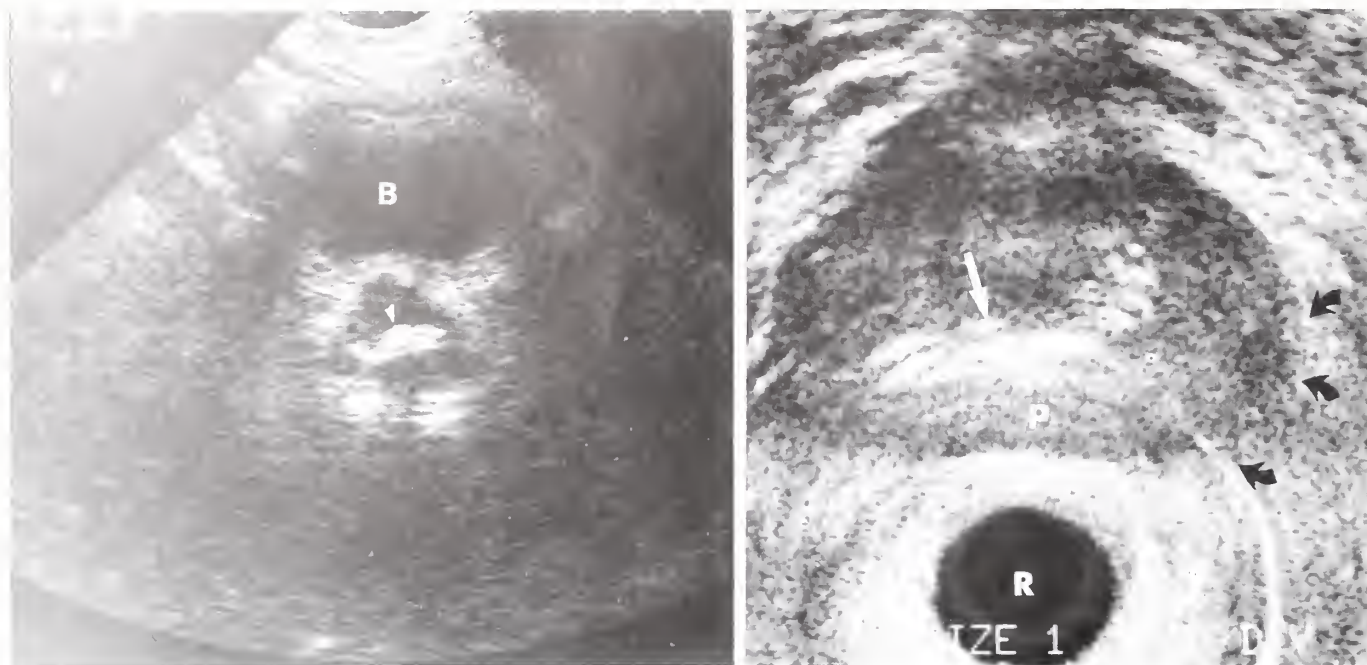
Stage B2 prostate carcinoma. *Left:* Transabdominal ultrasound 3.5-MHz transducer. *Right:* Transrectal ultrasound 7.5 MHz. Calcifications (long arrow) are seen within the prostate. On a transrectal scan, calcifications are at the junction of the central gland and peripheral zone (P). Note bulging of the left lateral contour of the gland (arrows), and, although the margin appears indistinct, no periprostatic tumor extension was seen at surgery. Spatial resolution of the transrectal scan is superior to the transabdominal.
